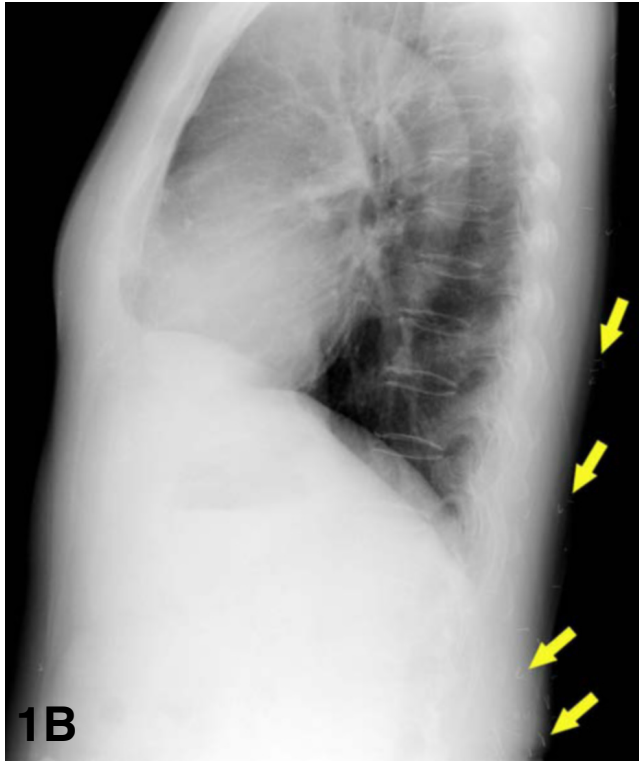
Lateral radiograph of the chest showing multiple retained acupuncture needles (arrows) in the soft tissues of the back and anterior abdominal wall.
